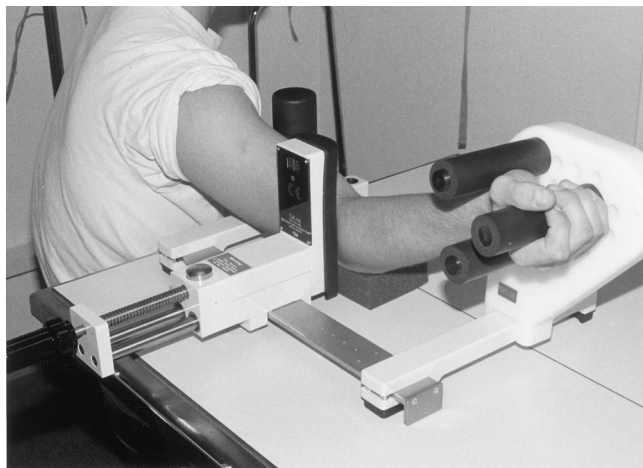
A Telos GA-II-E stress radiography device set up for the right elbow.
